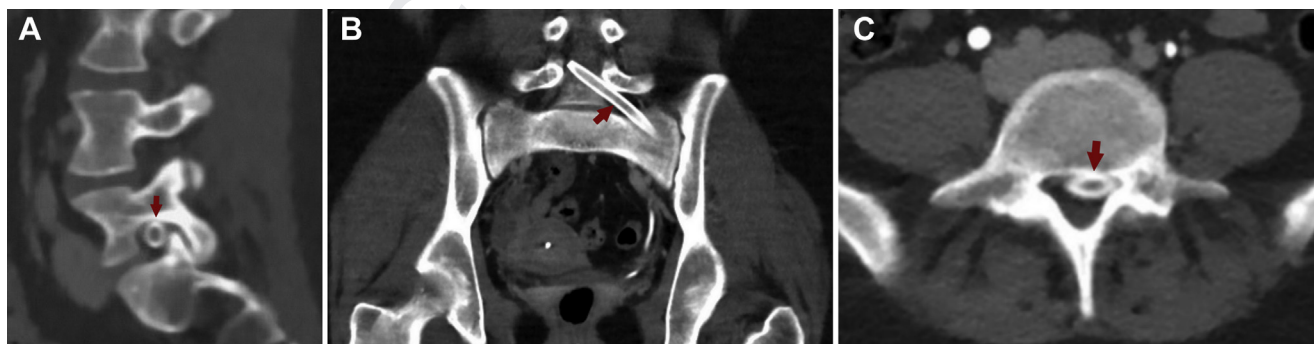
Preoperative computed tomography scan (sagittal, coronal, and axial views) showing stent (red arrows) deployment into the spinal canal
